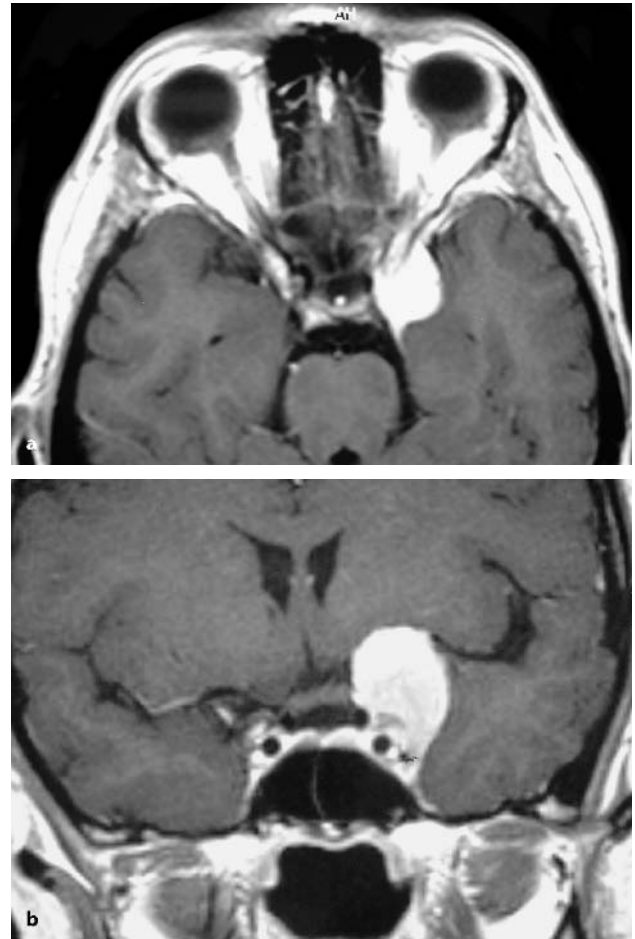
Meningioma of the left clinoid process in axial (a) and coronal (b) planes of contrast-enhanced T₁-weighted MR images. Patient positioning and skin incision behind the hairline for a frontolateral approach to remove this lesion (c)
